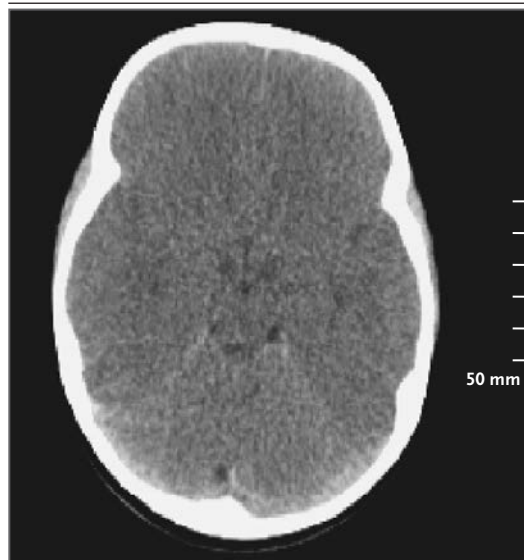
CT Scan of the Head of a 30-Month-Old Toddler with a History of Falling from a Standing Position.
